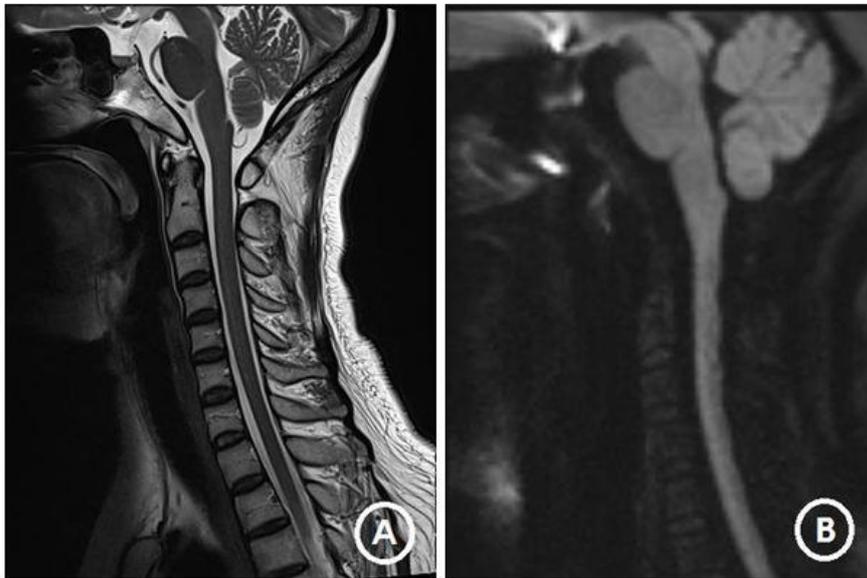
Cervical MRI was taken about an hour after the symptom onset. (A) T2-weighted image and (B) Diffusion-weighted image showed no signal change throughout the cervical spinal cord.
